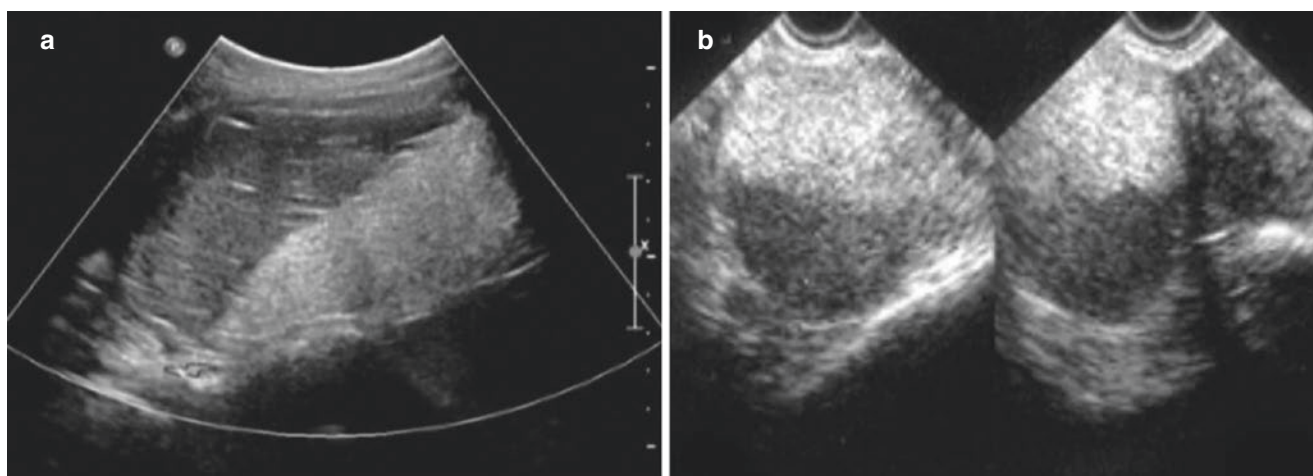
Ovarian teratoma (III). (a, b) Ultrasound image shows the mass with fat-fluid level. The hyperechoic fatty tissue located in the upper part
